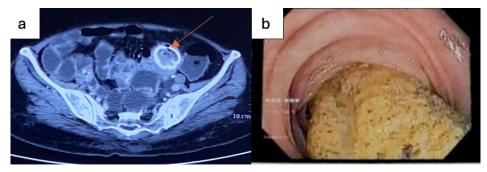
Pre-operative CT Entero-graphy and Colonoscopy. a. Arrow showing presence of Fistula and Intraluminal Phytobezoar. b. Presence of a greenish colored endoluminal mass inside the transverse colon extending up to the Descending colon
